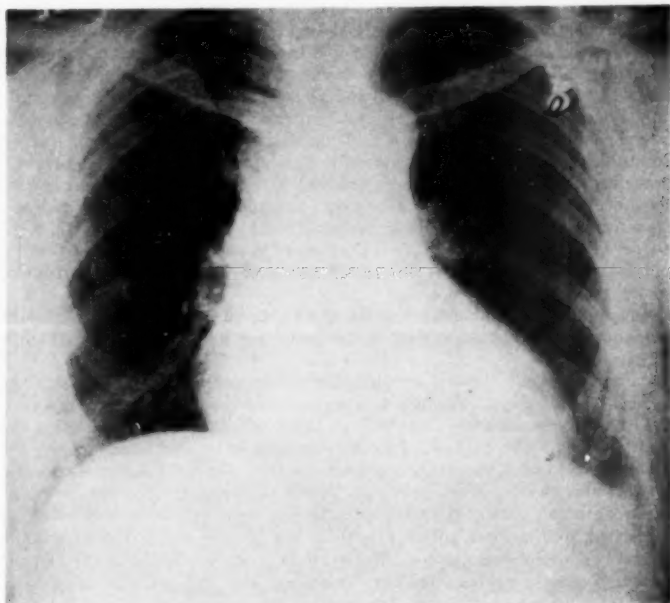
Case 2. Chest roentgenogram on fifth day of ACTH therapy. Infiltration has disappeared.
